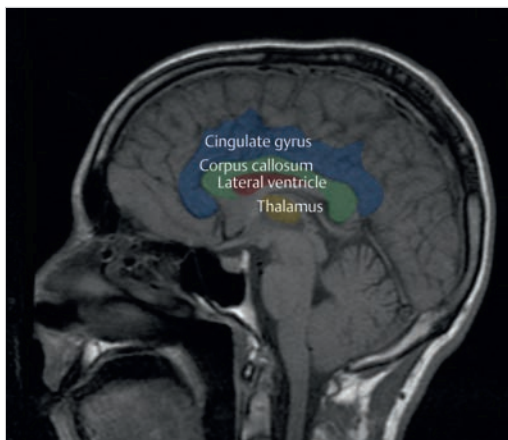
Midline, sagittal T1-weighted MRI with highlighted cingulate gyrus, corpus callosum, lateral ventricle, and thalamus as relevant anatomy to the interhemispheric transcallosal approach to intraventricular lesions.
